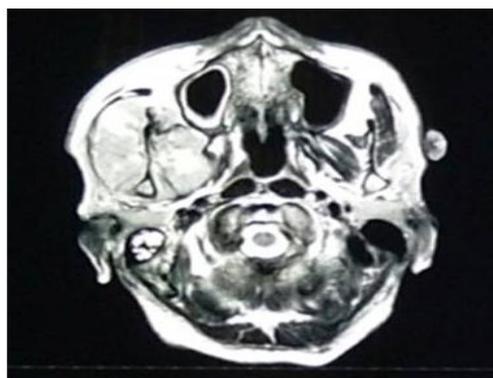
MRI of face showing lytic destruction of ramus and coronoid process on right side of mandible with large extraosseous component.
